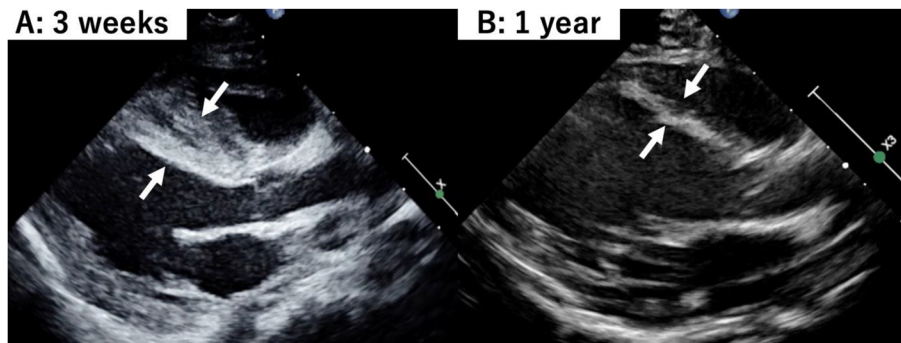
(A) TTE shows a nearly normal septal thickness at discharge (white arrow). (B) TTE 1 year after surgery shows thinning of the ventricular septum (white arrow). TTE, transthoracic echocardiography.
